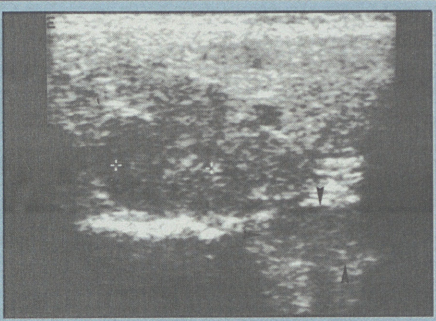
Longitudinal sonogram of the thyroid showing the ill defined edges of the nodule and extrathyroid extension (arrowheads). Calipers are inappropriately positioned.
